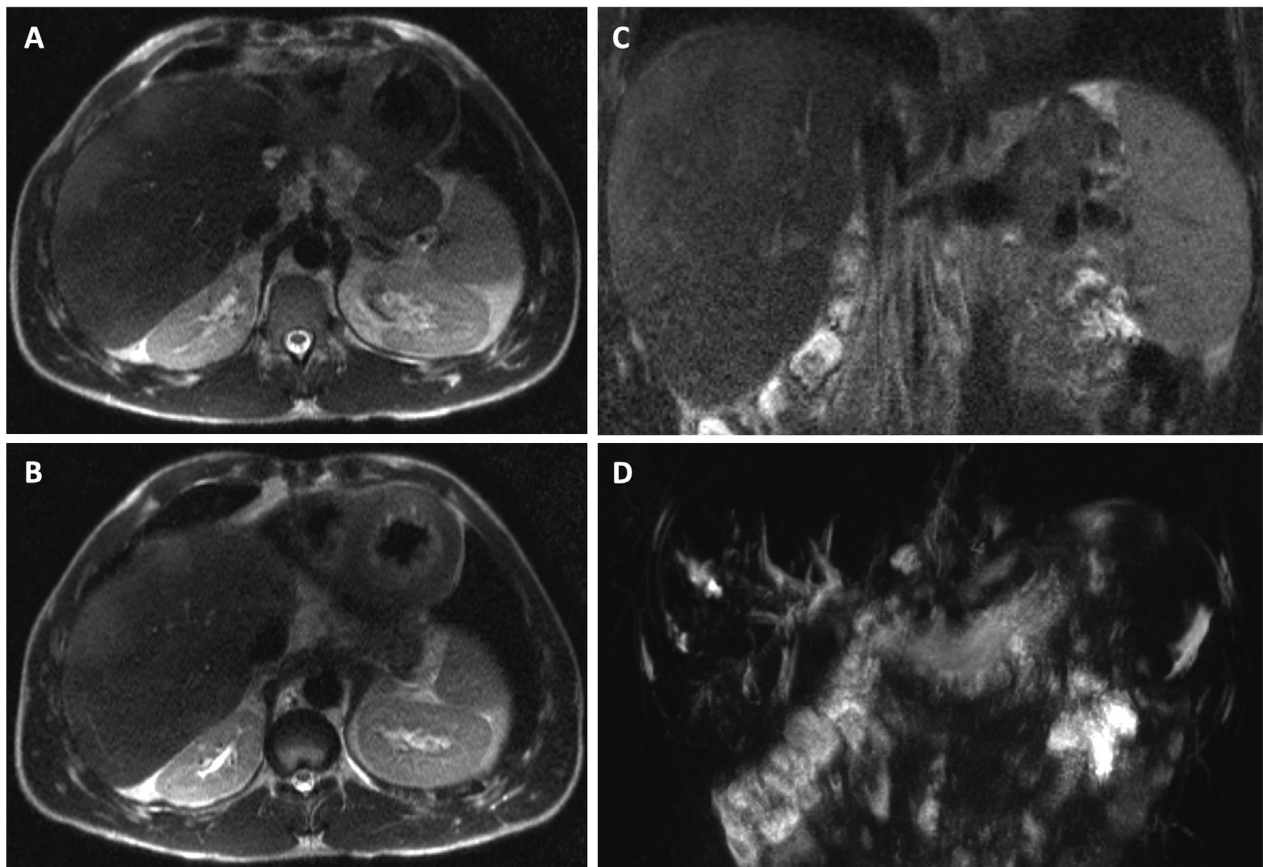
MRI of abdomen 6 months after removal of biliary drains. Axial (A and B), coronal (C), and MRCP (D) views. Liver transplant is noted in the right upper quadrant. There is no intrahepatic biliary dilatation or intraluminal gallstones.
